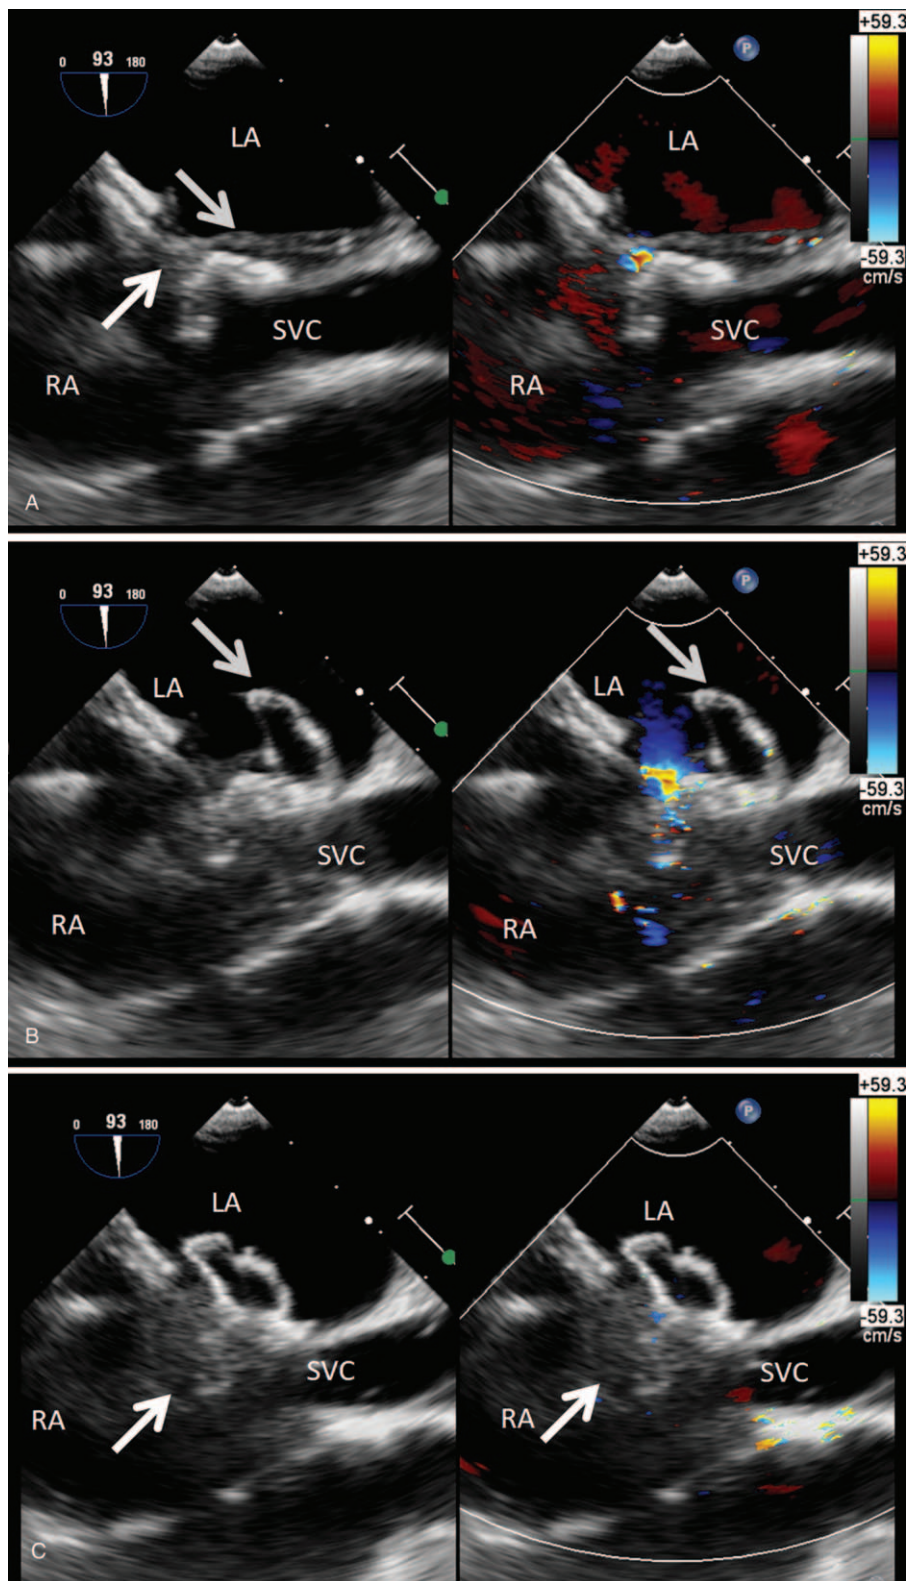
Color compared transesophageal echocardiography (TEE) guidance showing the procedural steps of the fenestration closure: (A) Sheath across the fenestration (arrows), (B) Deployment of the left disc (arrow), (C) Deployment of the right disc (arrow). LA=left atrium, RA=right atrium, SVC=superior vena cava.
